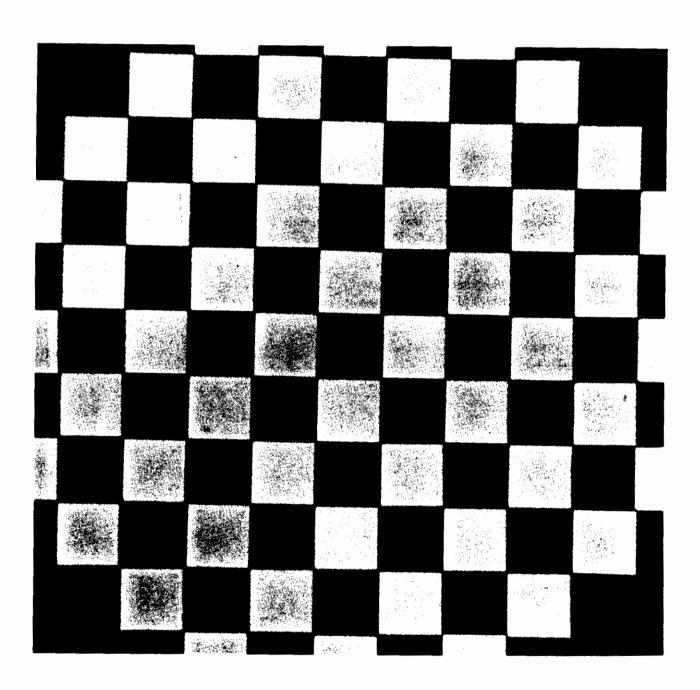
= Radiographic image of test object No. 1
